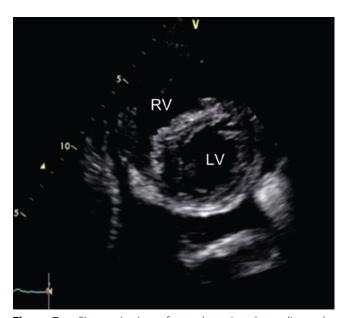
Short-axis view of transthoracic echocardiography after drainage of the pericardial effusion 6 months after atrial septal defect closure. The left ventricular shape became round, and the dimension of the left ventricle increased.
